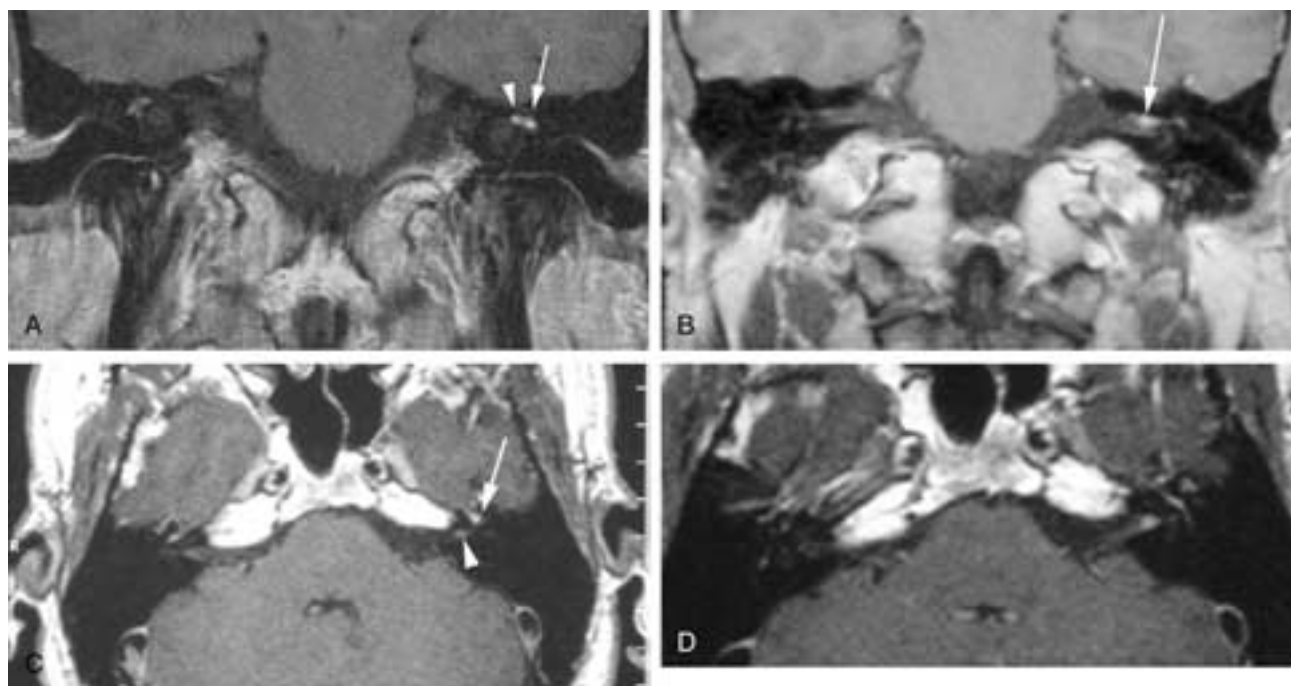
Bell's palsy (idiopathic facial paralysis). Post gadolinium T1-weighted MR imaging. A, The coronal plane shows the enhancing facial nerve. Both the labyrinthine segment (*arrowhead*) and the anterior tympanic segment (*arrow*) enhance compared to the opposite side. B, Slightly posterior to A. There is enhancement and enlargement of the facial nerve in the fundus of the internal auditory canal (*arrow*). This is typical of Bell's palsy and should not be considered evidence of a tumor. C, Axial image shows the enhancement in the region of the geniculate ganglion (*arrow*) and in the internal auditory canal (*arrowhead*). D, Slightly inferiorly to C. There is enhancement of the anterior tympanic segment (*arrow*). Note also the enhancement of the enlarged nerve within the internal auditory canal (*arrowhead*).
